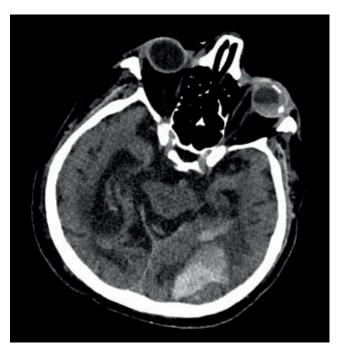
In the axial unenhanced CT image, bleeding products that level the left bulbus oculi and intraparenchymal hemorrhage in an area of approximately 5 cm at the level of the left parietooccipital borderzone are observed.
